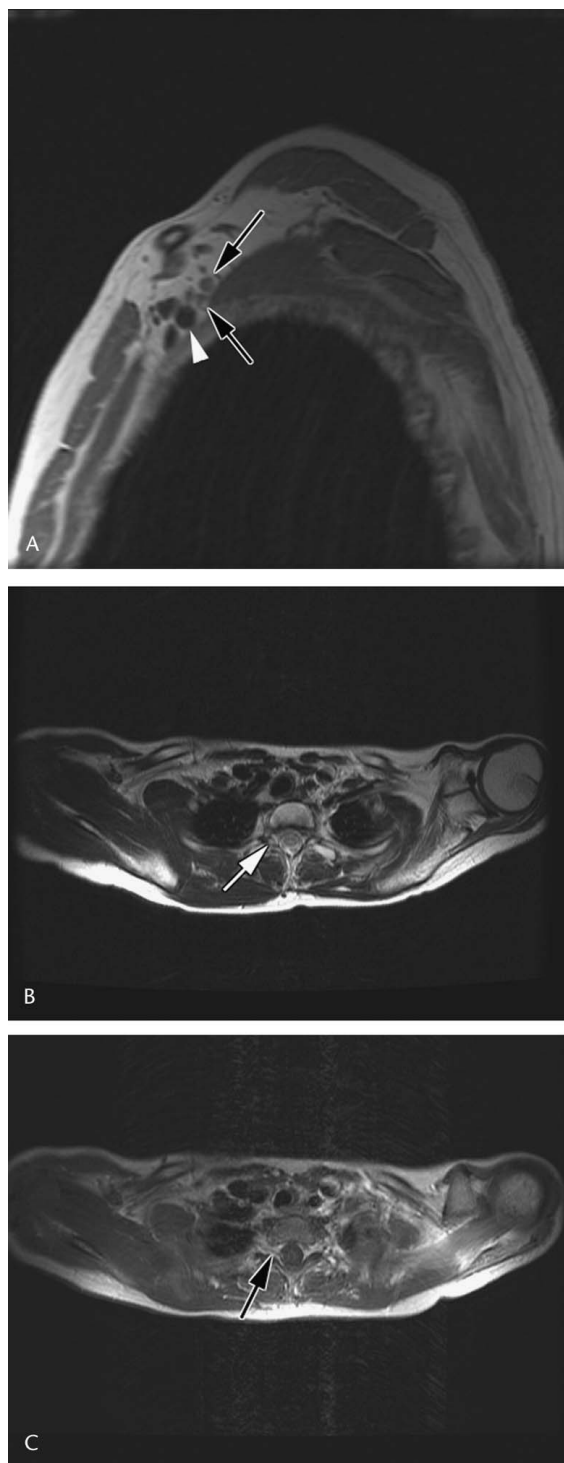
Sagittal and axial MRI imaging of the normal brachial plexus. A, Sagittal T1-weighted image demonstrating brachial plexus divisions (arrows) adjacent to the subclavian artery (arrowhead). B, T2-weighted image demonstration the nerve roots exiting the neural foramen and divisions adjacent to subclavian artery. C, T1-weighted image demonstration the nerve roots (arrow) exiting the neural foramen and divisions with relation to subclavian artery
